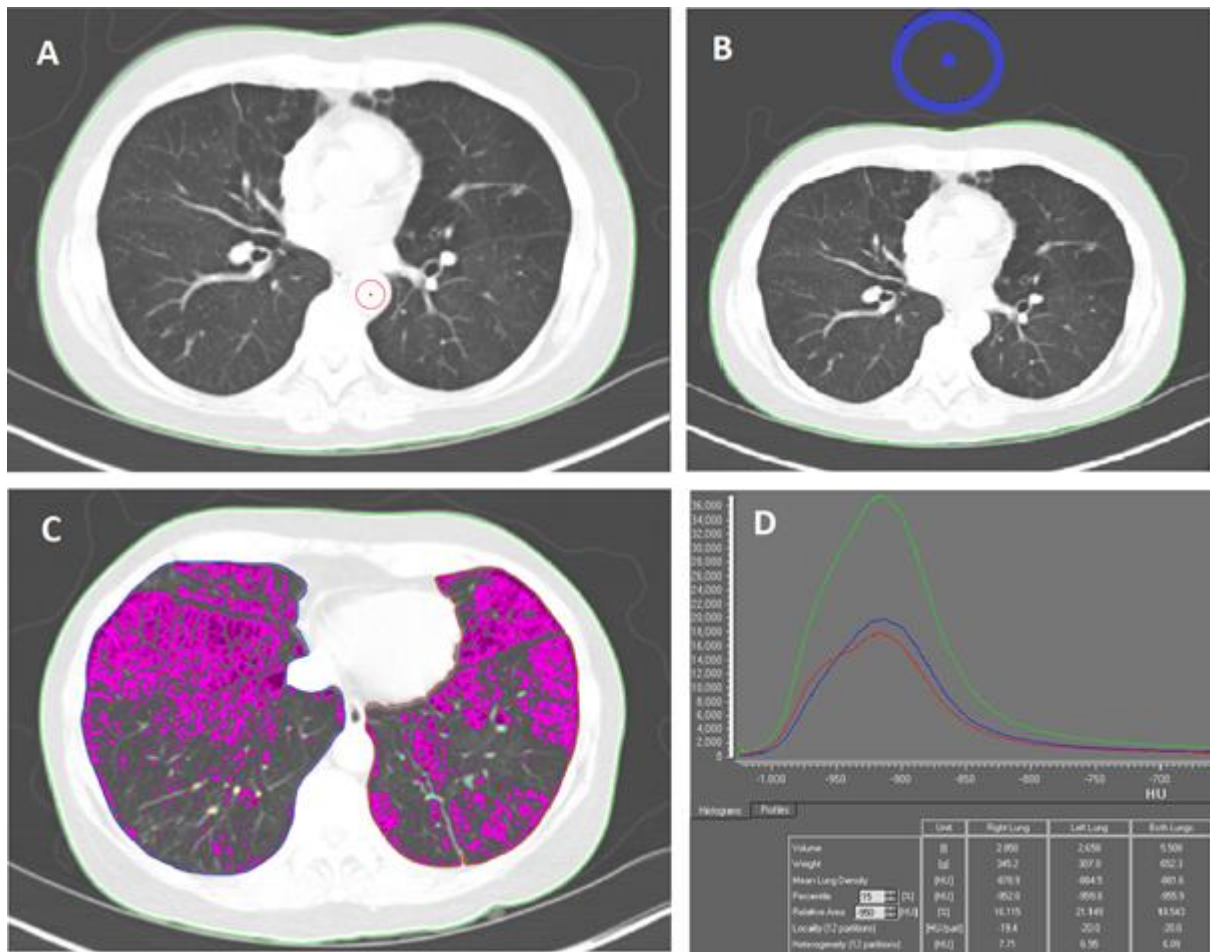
Demonstration of CT densitometry analysis using the PULMO CMS software.
